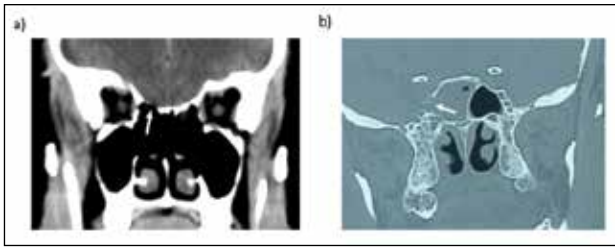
Representative perioperative CT scans from patients
